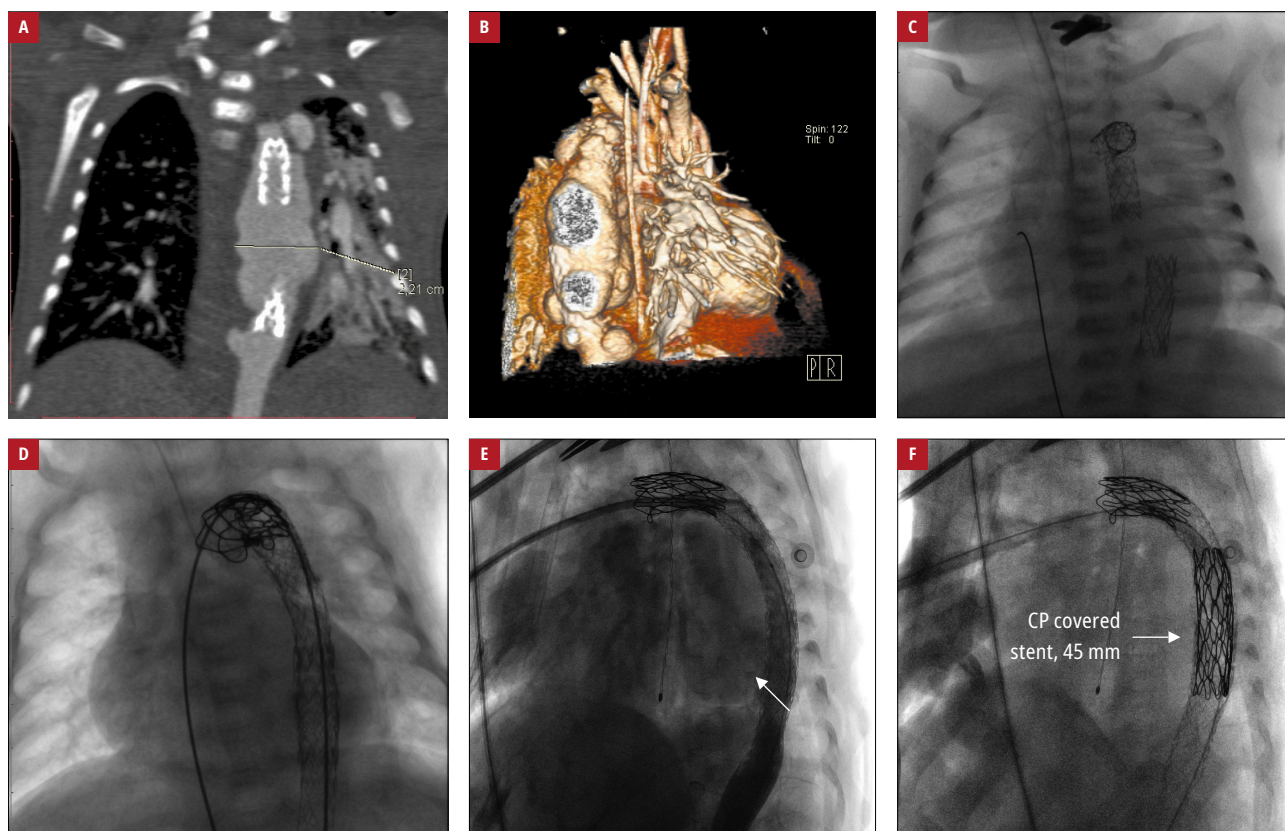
An infant with interrupted aortic arch type A and patent ductus arteriosus: A, B – computed tomography angiography conducted before the third catheterization, showing a large area of aortic dissection; C, D – angiography before (C) and after (D) the third very high-risk interventional procedure. Angiography during the last procedure: E – area of leakage (arrow), F – a covered stent implanted in the leakage area (arrow)
